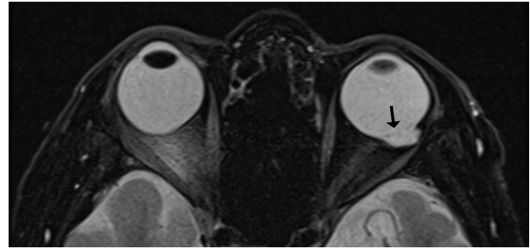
Axial T2-weighted fat-suppressed sequence showing left microphthalmia with a focal defect at the left posterior globe with associated vitreous humor herniation and retrobulbar cyst (*black arrow*).
